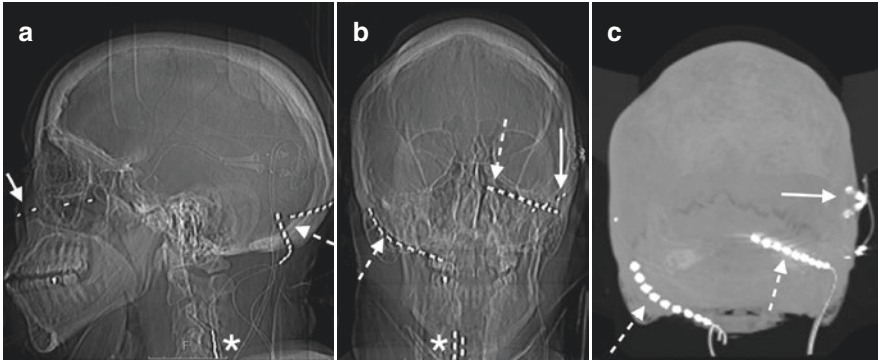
Sagittal (a) and frontal (b) scout images from a CT scan and a maximal intensity projection (MIP) reconstruction (c) reveal multiple implantable devices including a left V2 division stimulator device (solid arrow), bilateral occipital nerve stimulators (dashed arrows), and a cervical spinal stimulator within the dorsal epidural space at C4 (asterisk)
